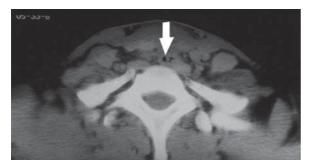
CT image of a patient with almost complete collapse of the airway
